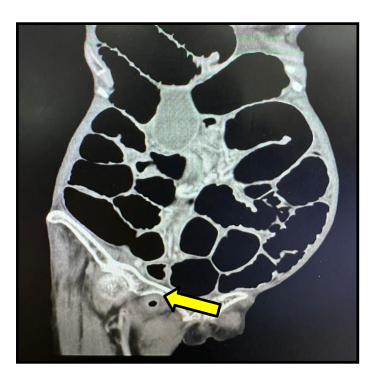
CT abdomen axial view showing grossly dilated bowel, yellow arrow pointing to right obturator bowel hernia
